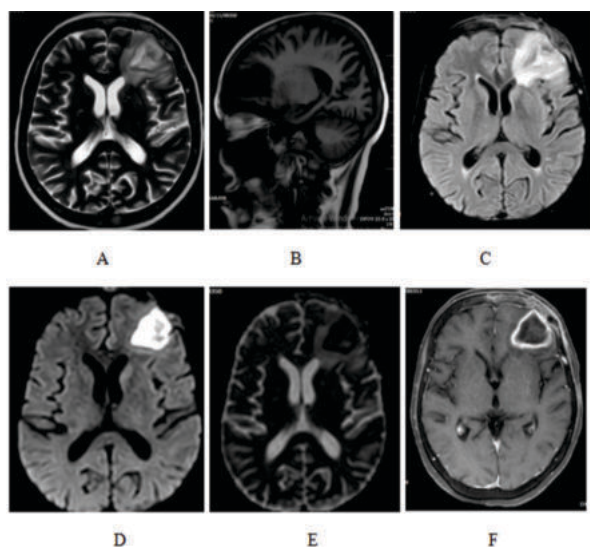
A – T2 WI hyperintense area in the left frontal lobe with surrounding edema. B- T1 WI corresponding area showing in the hypo intensity. C- corresponding area showing hyperintensity in the FLAIR imaging. D and E – DWI and ADC showing restriction in the DWI with low signal intensity in the ADC with ADC value of $0.6 \times 10^{-3} \text{ mm}^2/\text{sec}$ F- Post contrast showing peripheral thin smooth rim enhancement.
